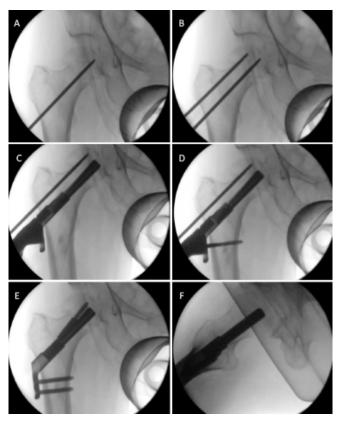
Intra-operative radiographic images of the FNS (Femoral Neck System) implantation. (A) AP view insertion of the guide-wire into the head of the femur. (B) Placement of an antirotation K-wire. (C) Insertion of the FNS implant after pre-drilling. (D) Predrilling of the locking screws. (E) FNS implant after the insertion of the antirotation screw. (F) Lateral view of the hip after full FNS implantation.
